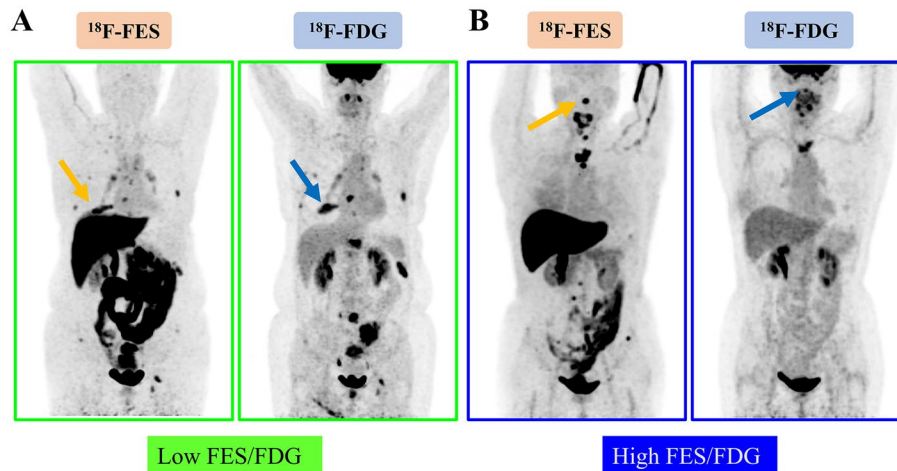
Representative imaging of patients with 100% FES-positive lesions. A Low FES/FDG (≤ 1.08). This 57-year-old woman has three lymph nodes and twelve bone metastases, all of which show positive results on FES and FDG PET scans. The representative lesion was located on the right side of the 9th rib, exhibiting SUVmax values of 7.8 and 8.7 for FES (yellow arrow) and FDG (blue arrow), respectively, with a FES/FDG ratio of 0.89. She was administered palbociclib in combination with letrozole as first-line therapy for a duration
